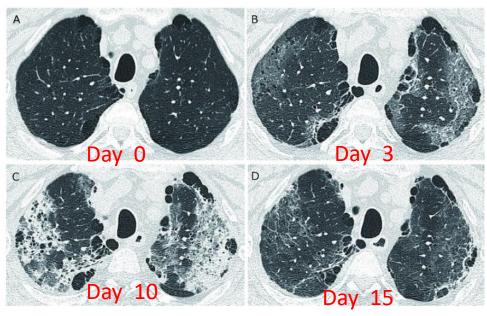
Chest CT images of the upper lobes of the lungs (A) day 0: there is no pneumonitis in upper lobes on admission. (B) day 3: Ground glass opacities have emerged. (C) day 10: the ground grass opacities have progressed to organising pneumonia. (D) day 15: the organising pneumonia has regressed but some ground grass opacities remain.
